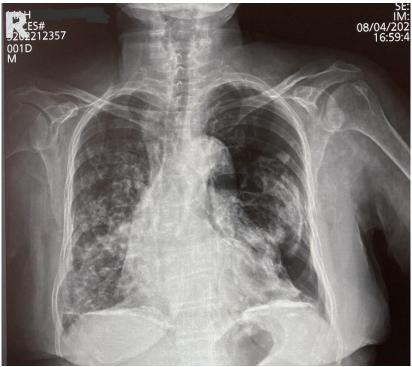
Chest radiograph – presentation of the left-sided total pneumothorax (case # 1).
